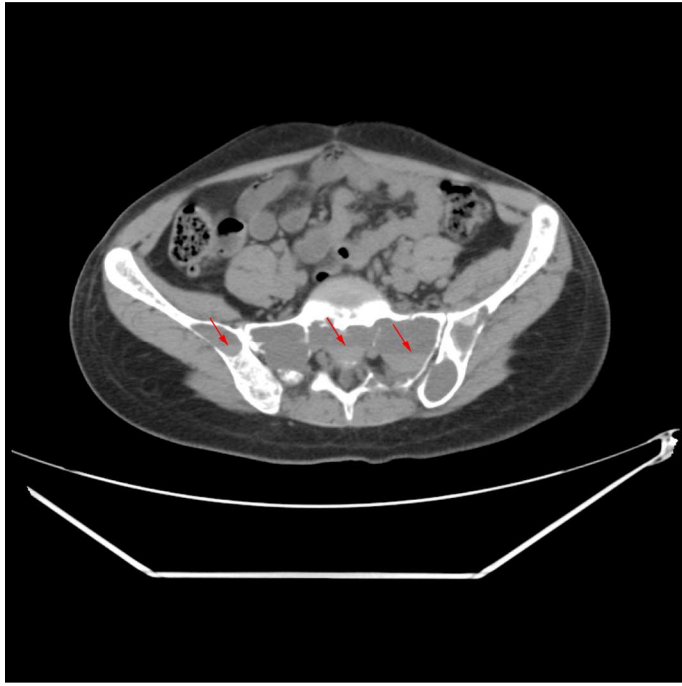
This unenhanced axial computed tomography (CT) image of the pelvis showed multiple lytic bone lesions with fluid-fluid levels (arrows).
